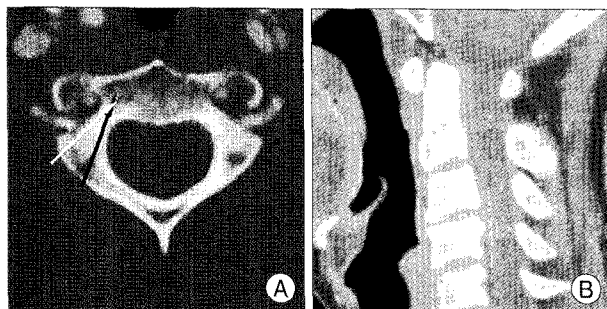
Preoperative computed tomography scan of C2 vertebra. (A) Axial image. Blue arrow indicates initially planned direction of screw and red arrow indicates incorrectly introduced direction of screw. (B) Sagittal image.
